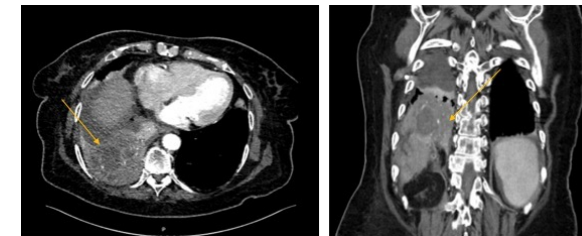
CT scan at 2 months
